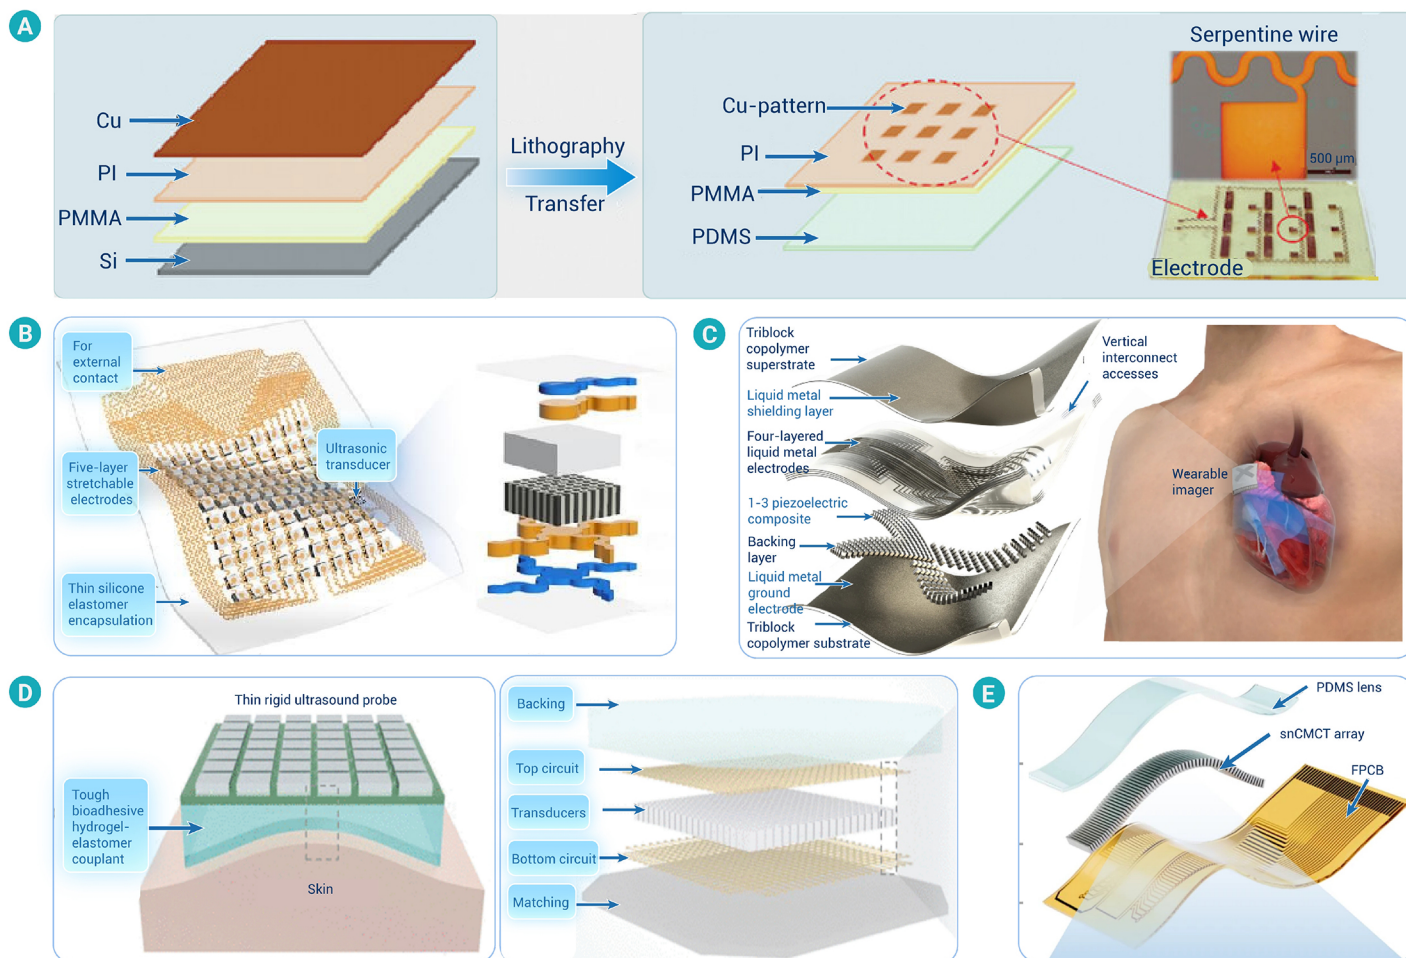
Structure of flexible ultrasound patches (A) Common flexible ultrasound patch structure and internal circuitry; Modified appropriately and reproduced with permission.¹⁶ Copyright 2021, Wiley. (B) 10×10 piezoelectric transducers arrays; Modified appropriately and reproduced with permission.¹⁸ Copyright 2018, American Association for the Advancement of Science. (C) Orthogonal piezoelectric array with liquid metal electrodes; Modified appropriately and reproduced with permission.¹⁹ Copyright 2023, Nature. (D) Structure of hydrogel coupling agent; Modified appropriately and reproduced with permission.²⁰ Copyright 2022, American Association for the Advancement of Science. (E) snCMUT array. Modified appropriately and reproduced with permission.¹⁰ Copyright 2025, Nature.
